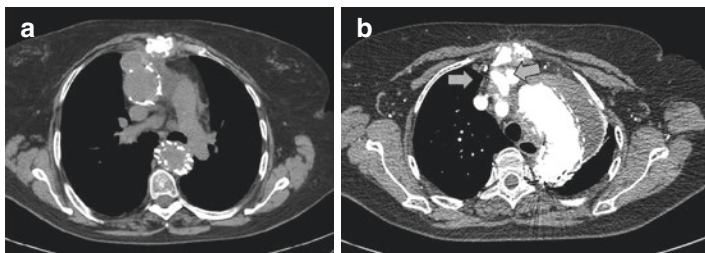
(a) Chest CT without contrast showing endoprosthesis in ascending and descending aorta as well as proximal origin of the bifurcated graft. (b) Contrasted chest CT showing both branches of the bifurcated graft anterior to the aorta (arrows)
